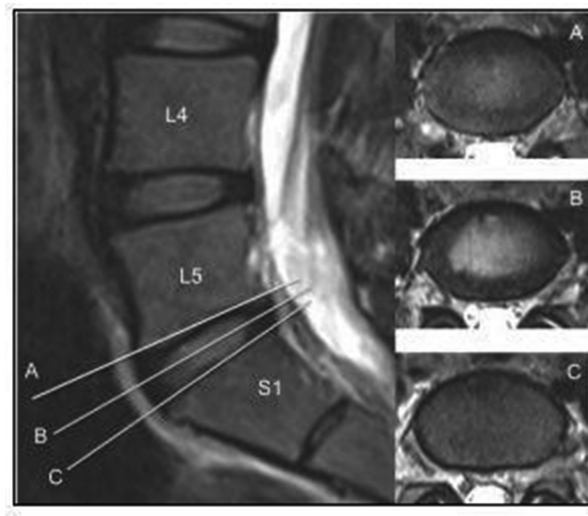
Sample of MRI scan in sagittal and transverse planes [18]
